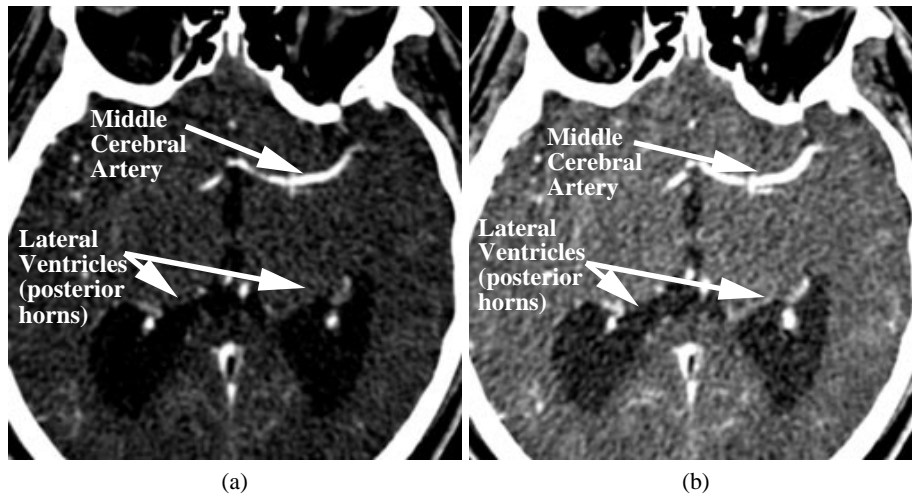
CT axial slice with the posterior horns of the lateral ventricles and middle cerebral artery. (a) Contrast window one, (b) Contrast window two.
